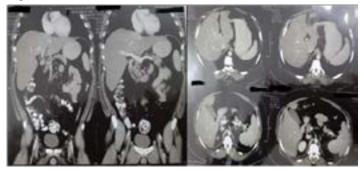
CT of follow up after more than one year
